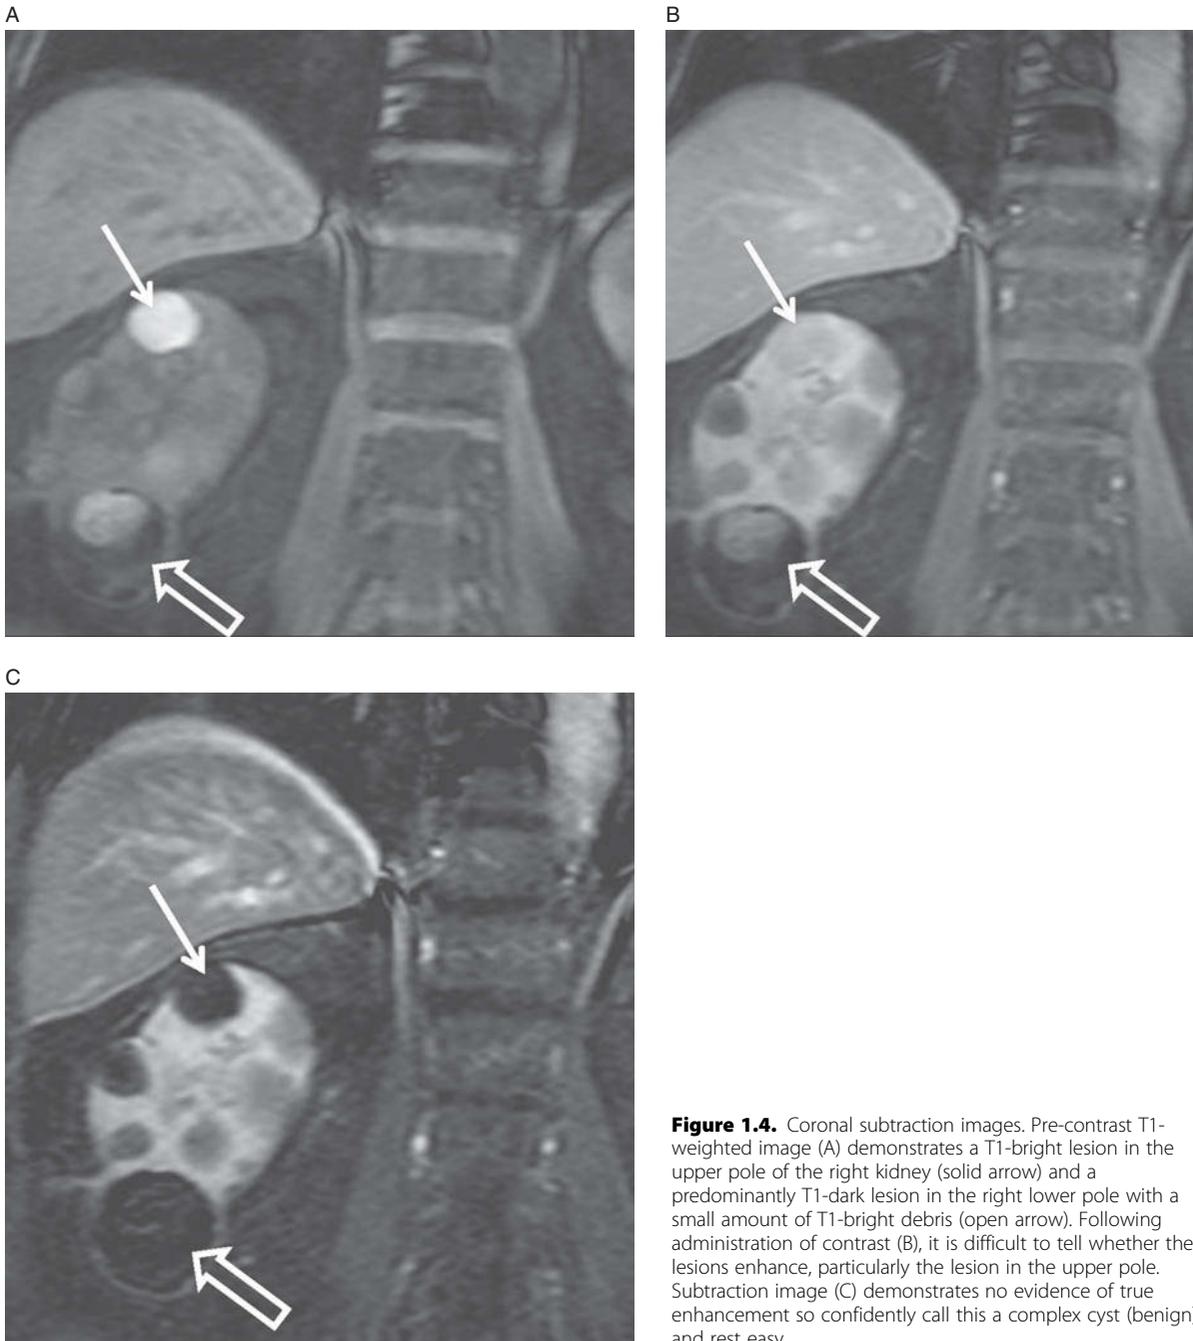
Coronal subtraction images. Pre-contrast T1-weighted image (A) demonstrates a T1-bright lesion in the upper pole of the right kidney (solid arrow) and a predominantly T1-dark lesion in the right lower pole with a small amount of T1-bright debris (open arrow). Following administration of contrast (B), it is difficult to tell whether the lesions enhance, particularly the lesion in the upper pole. Subtraction image (C) demonstrates no evidence of true enhancement so confidently call this a complex cyst (benign) and rest easy.
